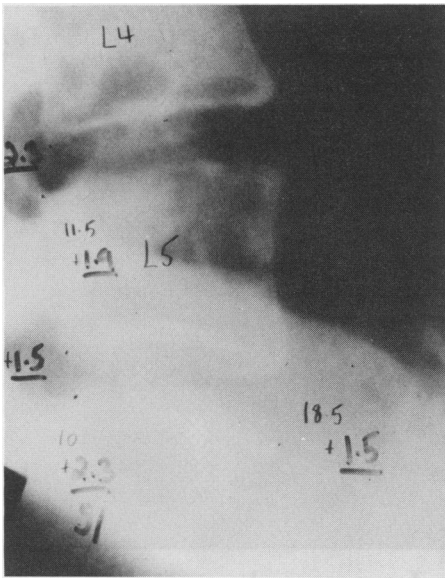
Patient #1. Post-Inversion radiograph. Underlined measurements have been reduced by a factor of 1.3.
